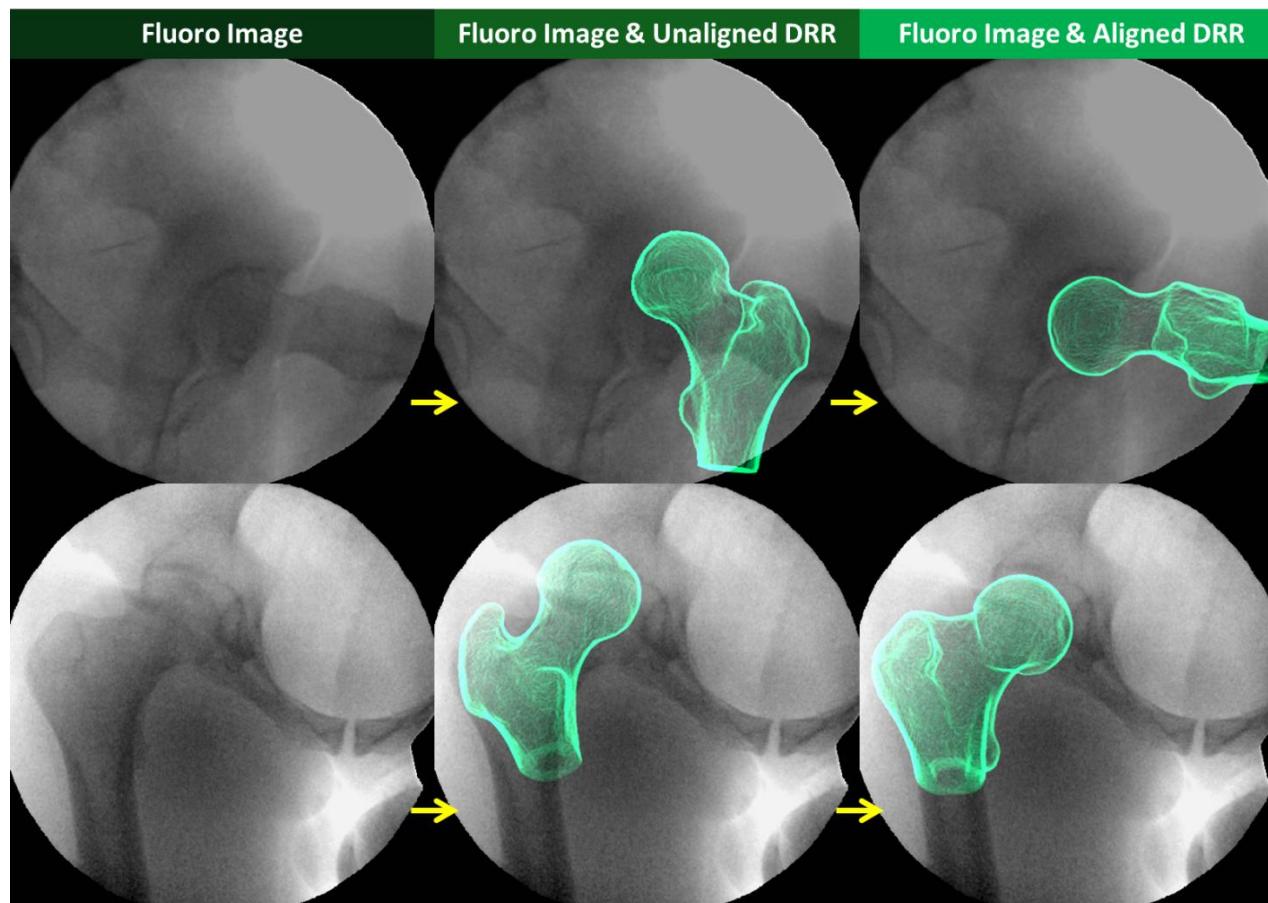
Model-based tracking. Images of the same joint are acquired by two synced fluoroscopes (top and bottom rows) and loaded into model-based tracking software. Previous calibration steps established the relative configuration and perspective of the two fluoroscopes, and the user interface is initialized with digitally reconstructed radiographs (DRRs) of the bone of interest overlaid on the fluoroscopy images in an unaligned position. The model-based tracking software then optimizes the pixel intensity agreement between the DRR and the original video to align the bone to its in vivo position. The process is repeated for all frames of the video.
